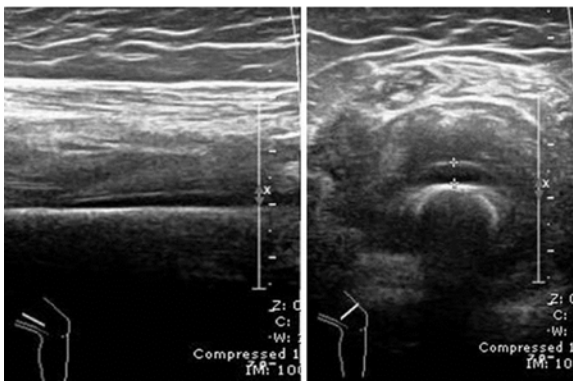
The ultrasonography of the left lower extremity, Right: heterogenous echogenicity of the left proximal quadriceps muscles indicated subperiosteal fluid collection, and Left: left knee effusion.
